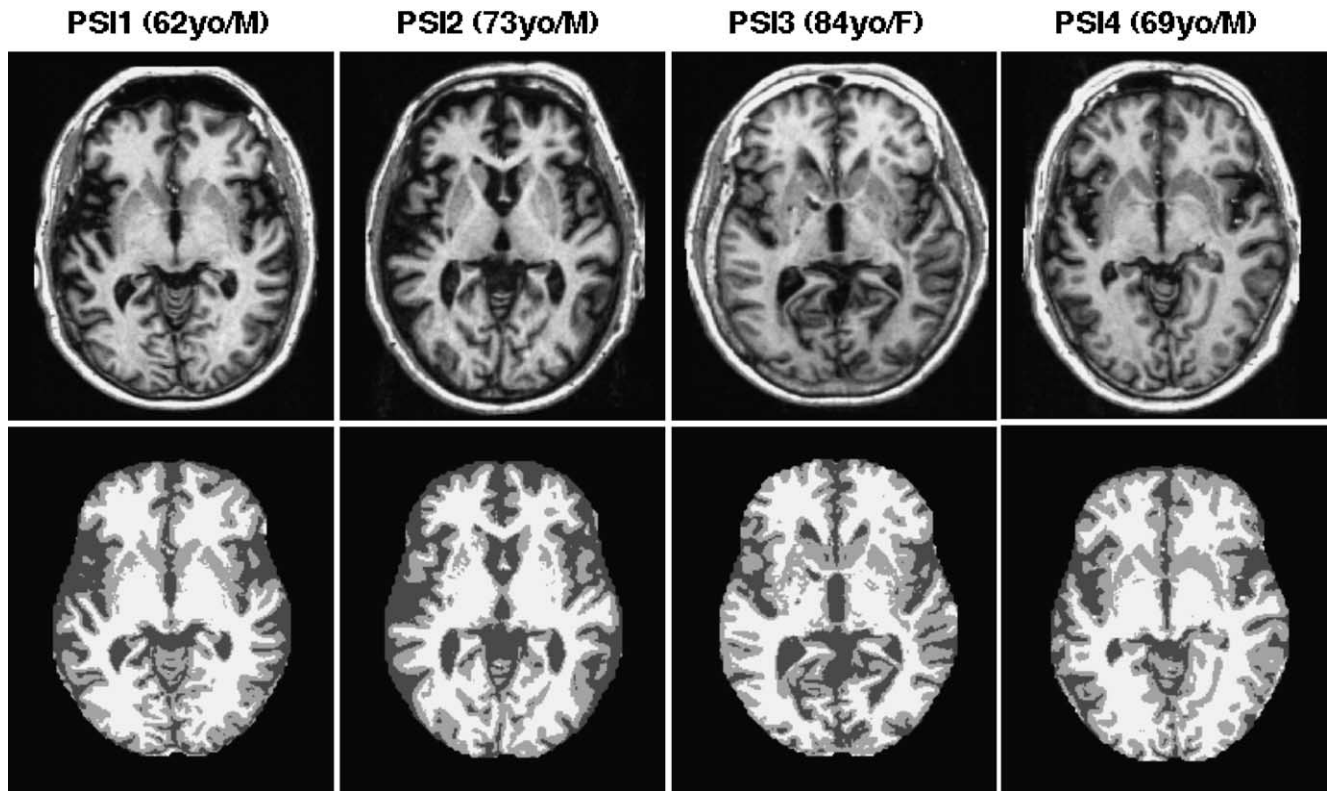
MRI structural images of the four individuals with PSI. The top row shows a representative axial section from the raw structural image of each participant, averaged in atlas-transformed space. The images are labeled at the top with the specific PSI participant including age in years-old (yo) and gender. The bottom row shows the segmented images with the darkest gray representing cerebral spinal fluid (CSF), medium gray representing gray matter, and white representing white matter.
